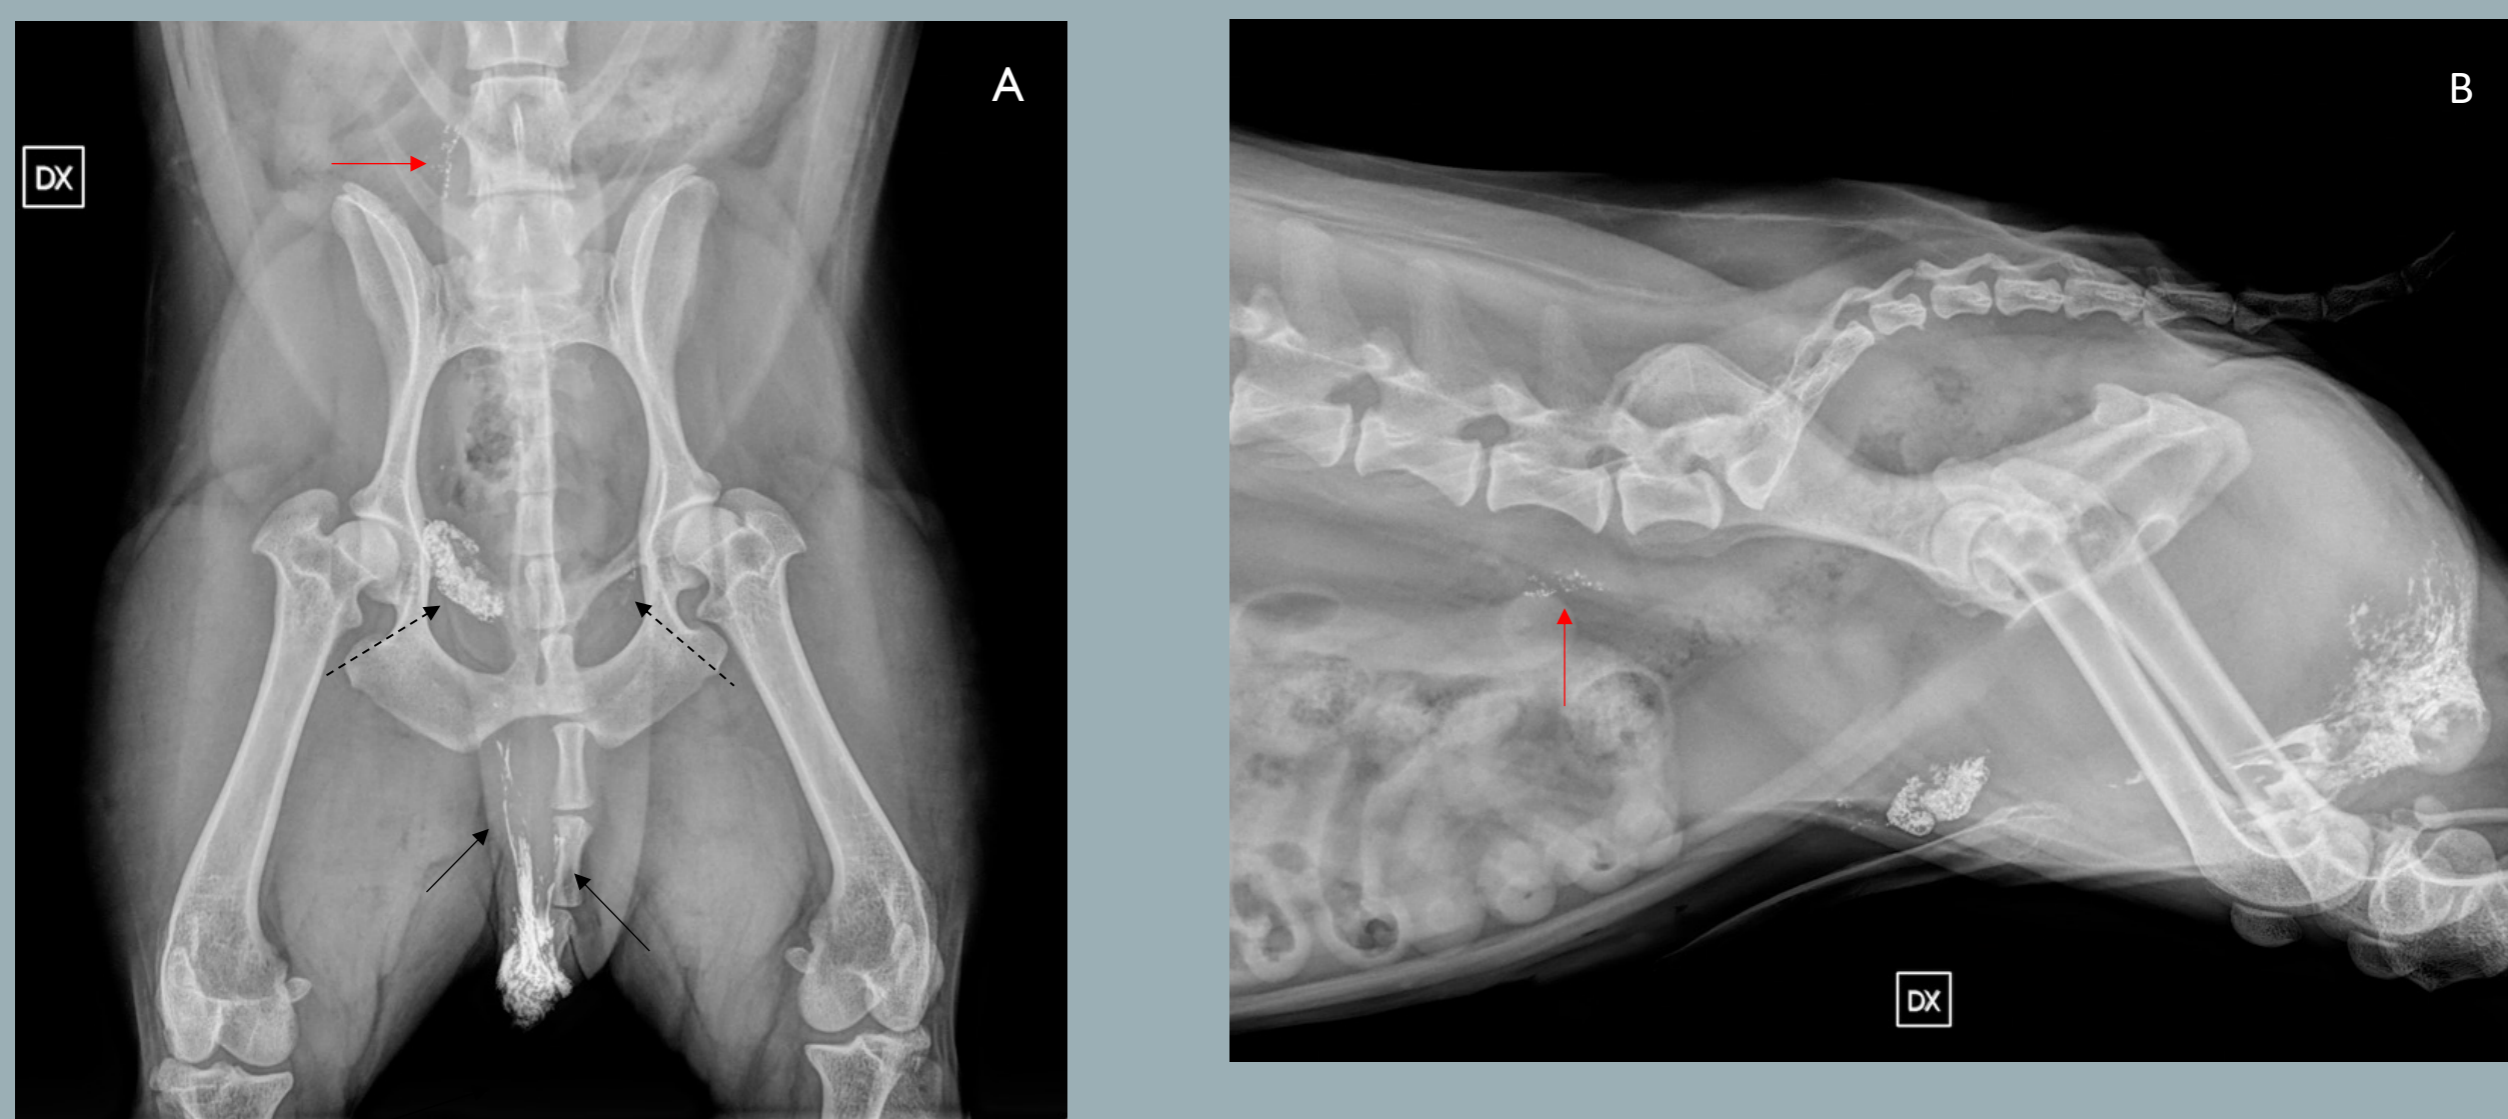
Radiographic indirect lymphangiography 24 hours post Lipiodol in two orthogonal views of a MCT in the scrotum with three SLNs: (A) VD view of the pelvic region. Lymphatic vessels are visible on both views extending cranially (*black arrows*), inguinal lymph nodes are highlighted by the (*black dashed arrow*); (B) Right lateral view of the pelvic region. The right medial iliac SLN can be assessed ventrally to L6 and to the right of L6 in the VD highlighted by the *red arrow*.
